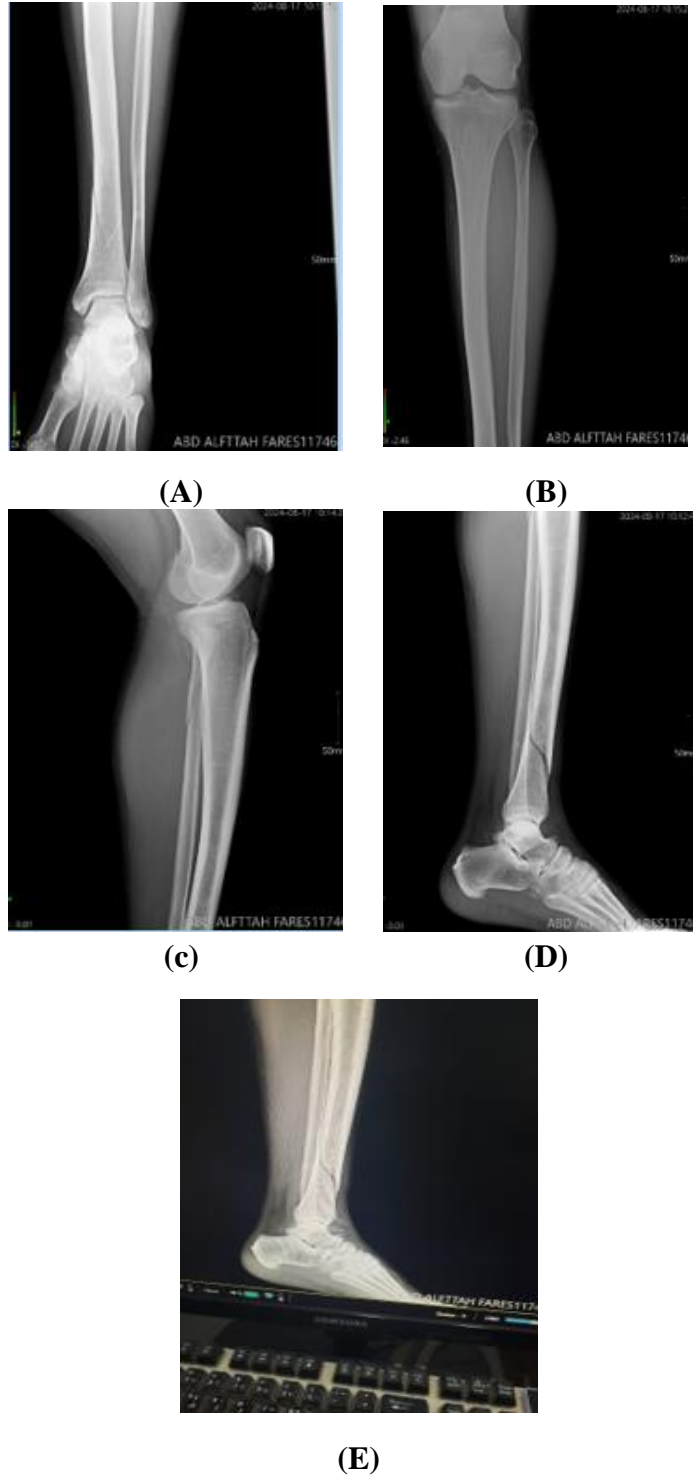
(A) and (B) Pre-operative X-rays; AP, (C), (D) and (E) lateral view
